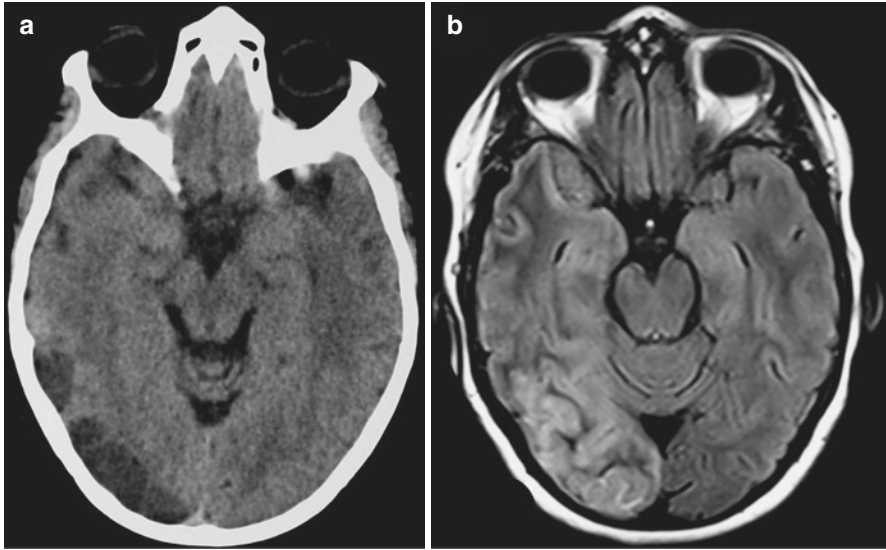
Cranial axial CT-scan: suspicion of “chronic heterogeneous subdural hematoma” on the right side (a). Axial MRI on FLAIR sequences showing brain area of ischemia (b). Note the brain edema, loss of gray-white differentiation, and no brain shift
